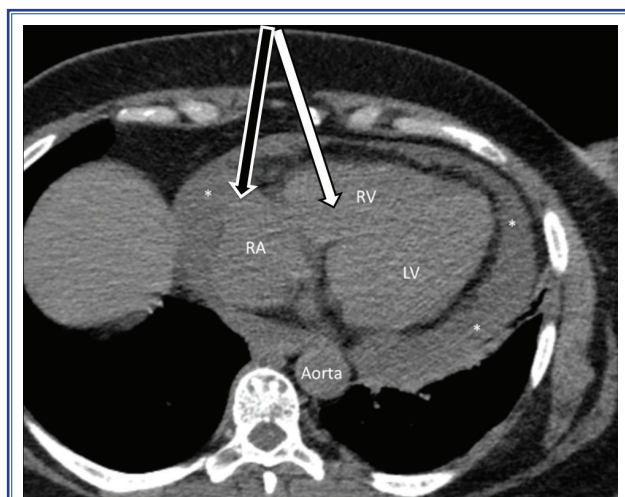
Computed tomography image showing pericardial effusion and catheters placed in right ventricle (white arrow) and pericardial cavity (black arrow). RA: Right atrium; RV: Right ventricle; LV: Left ventricle; (*) Pericardial effusion.
